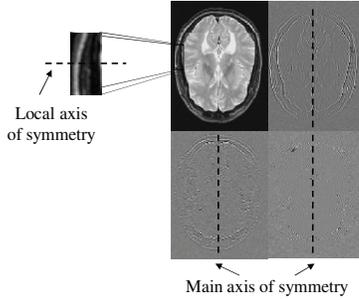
Example 2D-IWT sub-bands for one level of decomposition of an axial view slice of a brain MRI scan. Note the global and local symmetries of the sub-bands.
